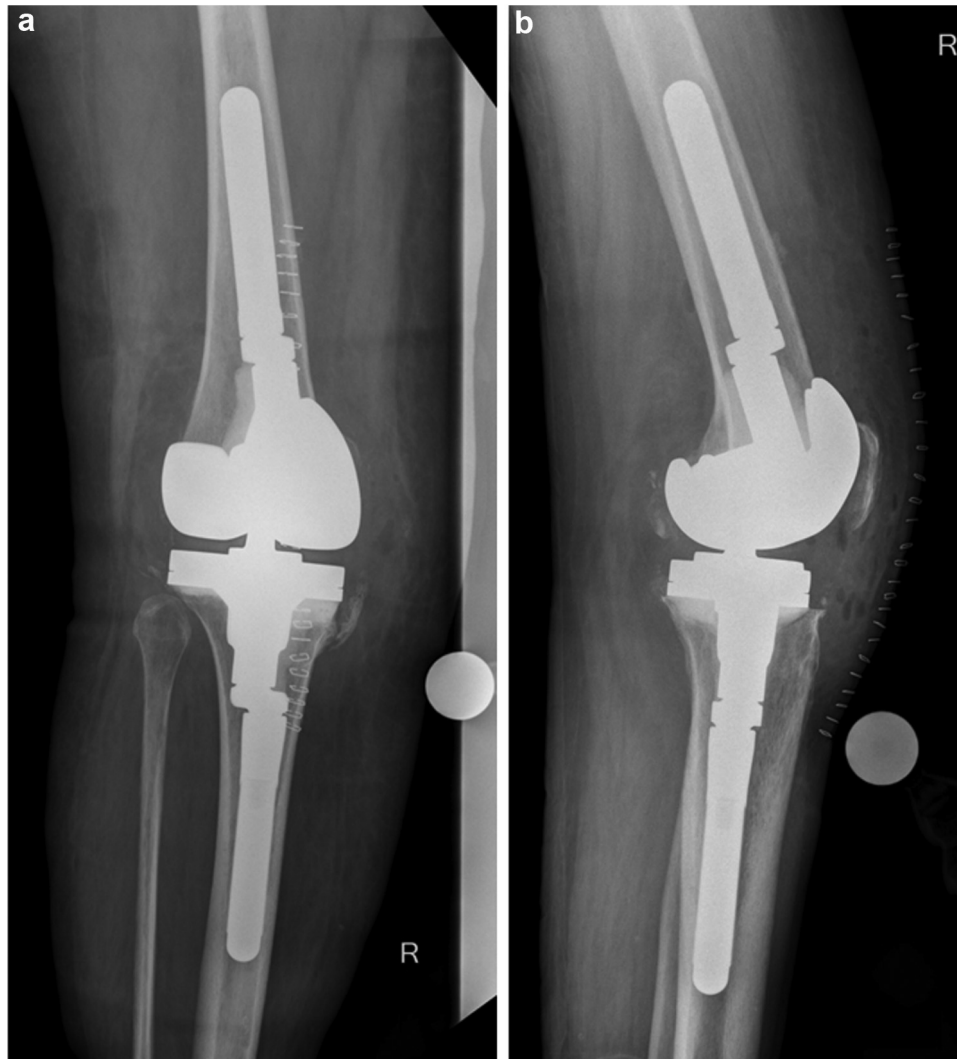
Anteroposterior (a) and lateral (b) radiographs of the right knee after reimplantation of a rotating-hinge revision TKA.
